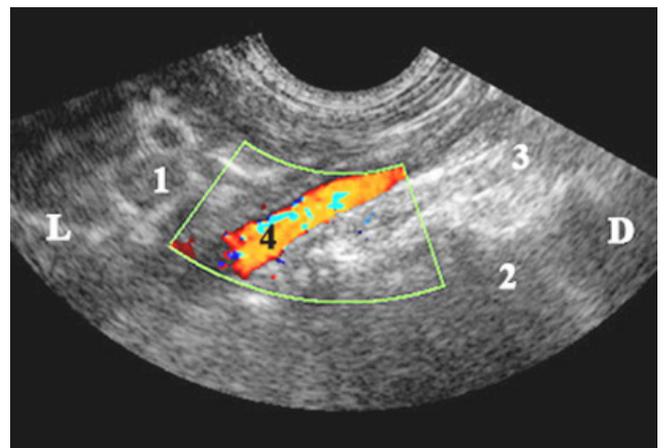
Color Doppler US image of the abdominal aorta close to the liver (Color and pulse Doppler transducer – 7.5 MHz). L –left; D –right. (1) stomach; (2) liver; (3) small intestines; (4) abdominal aorta
